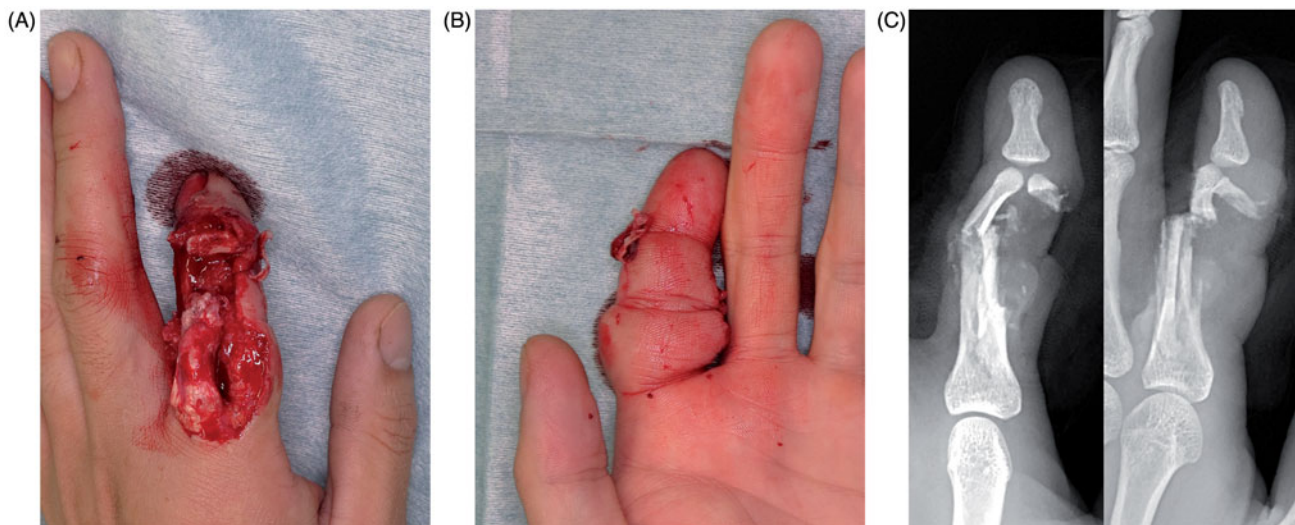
Case 2: left index finger on initial presentation. (A) Dorsal view showing skin defect and open fracture. (B) Volar site of the finger remains intact. (C) X-ray depicting comminuted fracture. Frontal and lateral view.
